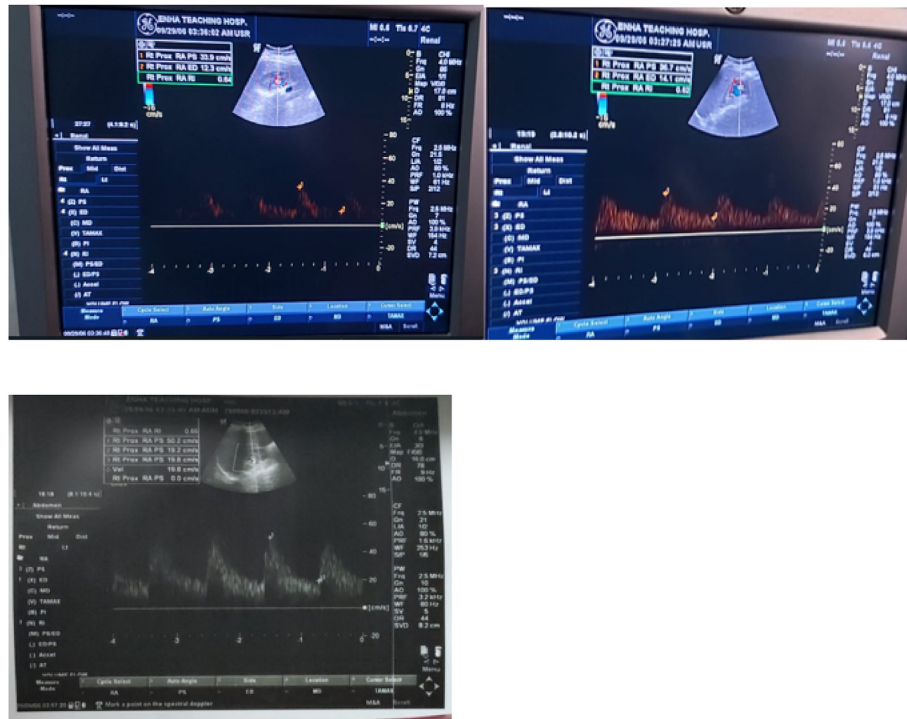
Ultrasound color Doppler of the right interlobar renal artery of three different cases showed elevated renal resistive index.
